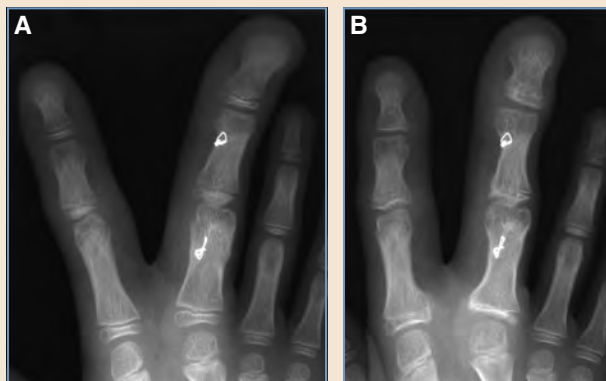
A combination of epiphysiodesis and closing wedge osteotomies to correct angulation and arrest longitudinal growth. A, A radiograph obtained 1 year after closing wedge osteotomies at the junction of the middle and distal thirds of both the proximal and middle phalanges of the middle finger and before an epiphysiodesis. B, A radiograph obtained 16 months after an epiphysiodesis of all phalanges of the index and middle fingers, including closing wedge osteotomies at the level of the epiphysiodesis for the proximal phalanx of the index finger and both proximal and distal phalanges of the middle finger.
